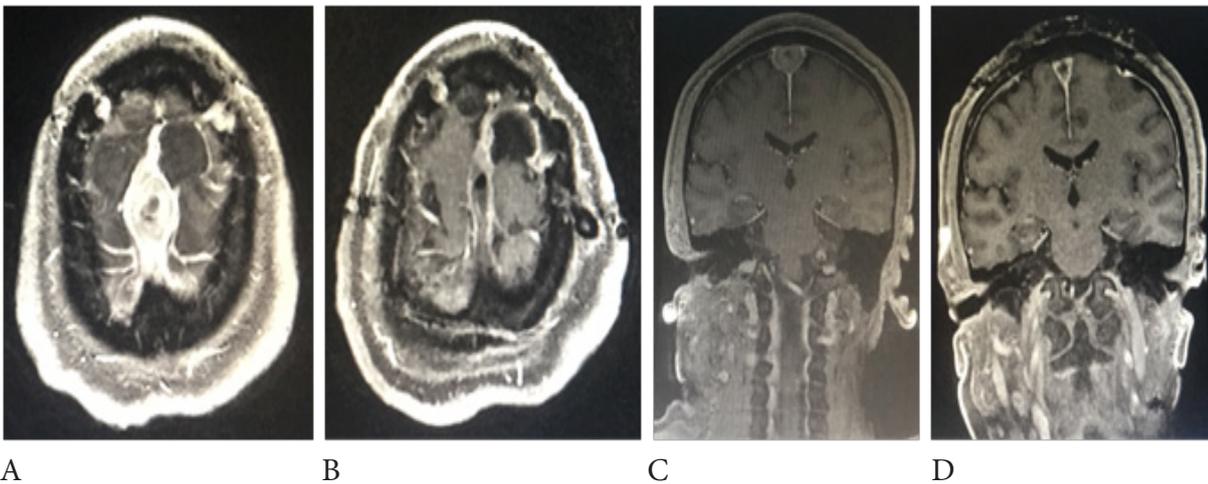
A-B PreOp and PosOp Contrast enhanced axial MRI comparison. C-D, PreOp and PosOp Contrast enhanced coronal MRI comparison.
